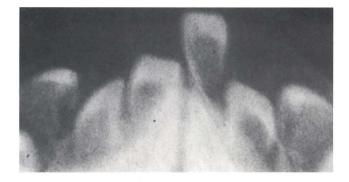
Occlusal radiograph of the mandibular anterior area shortly after birth. Note the rootless, shell like, superficially located tooth structures.
